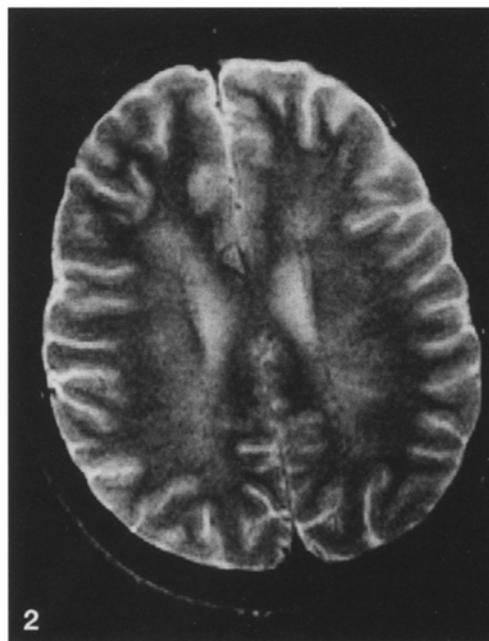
Axial T2-weighted image. MR performed 3 months after fat embolism showed a marked reduction of signal alterations in cerebral white matter
